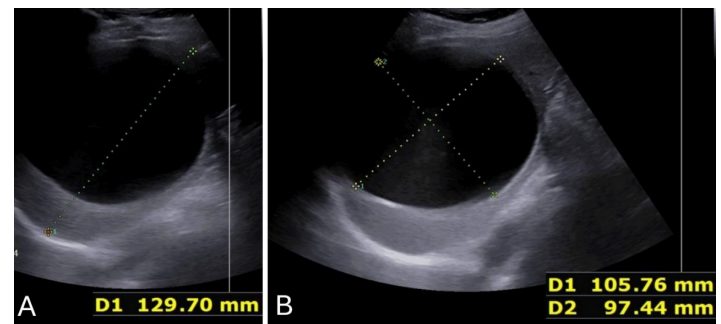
An abdominal ultrasound demonstrates a solitary giant lesion with pure fluid with no internal septations or internal solids
